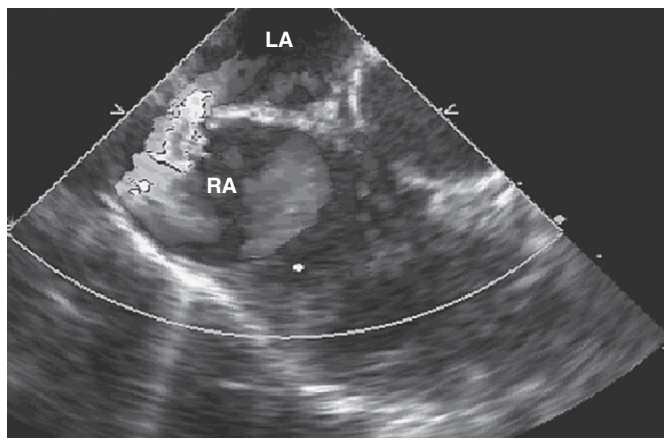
High sinus venosus atrial septal defect between the left atrium (LA) and right atrium (RA). Left-to-right shunting is seen by color Doppler (blue flow away from the transducer with aliasing).
